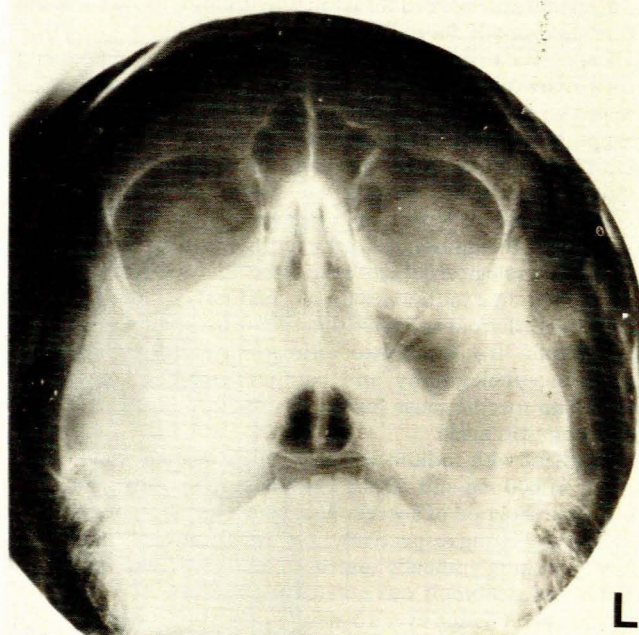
Occipitomental and lateral sinus radiographs showing a large calcified mass filling and expanding the entire right maxillary antrum.
